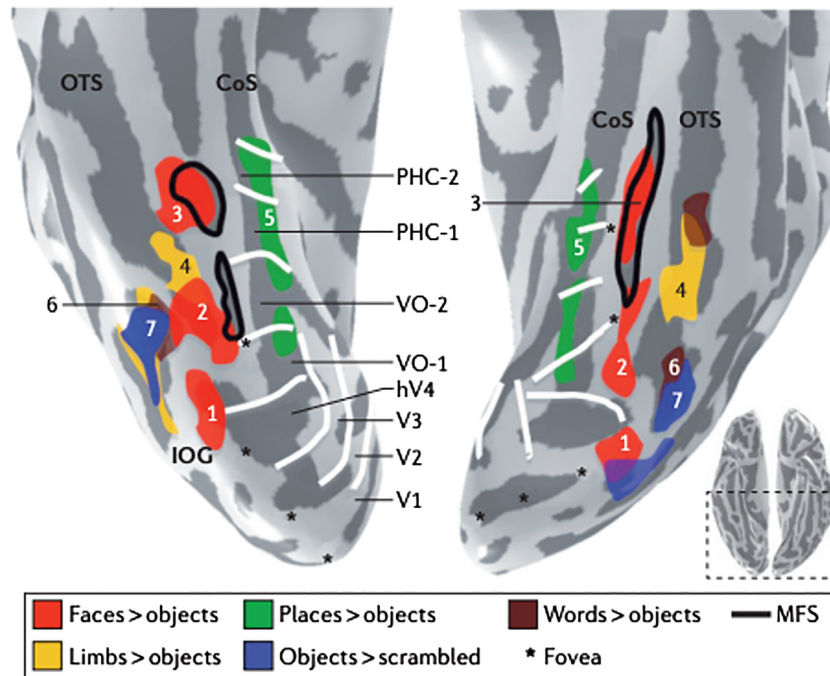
Functional MRI measurements have been used to identify small cortical regions that respond preferentially to specific stimulus classes: (faces, red), (places, green), (words, brown), (limbs, yellow) and (objects, blue). Locations are shown on the inflated hemispheres of a representative subject. These regions have a consistent spatial organization on the inferotemporal cortex, both with respect to one another, the sulcal pattern and the visual field maps. For example, place regions are medial to face regions, and limb regions separate two of the face regions. From Grill-Spector and Weiner (2014).
